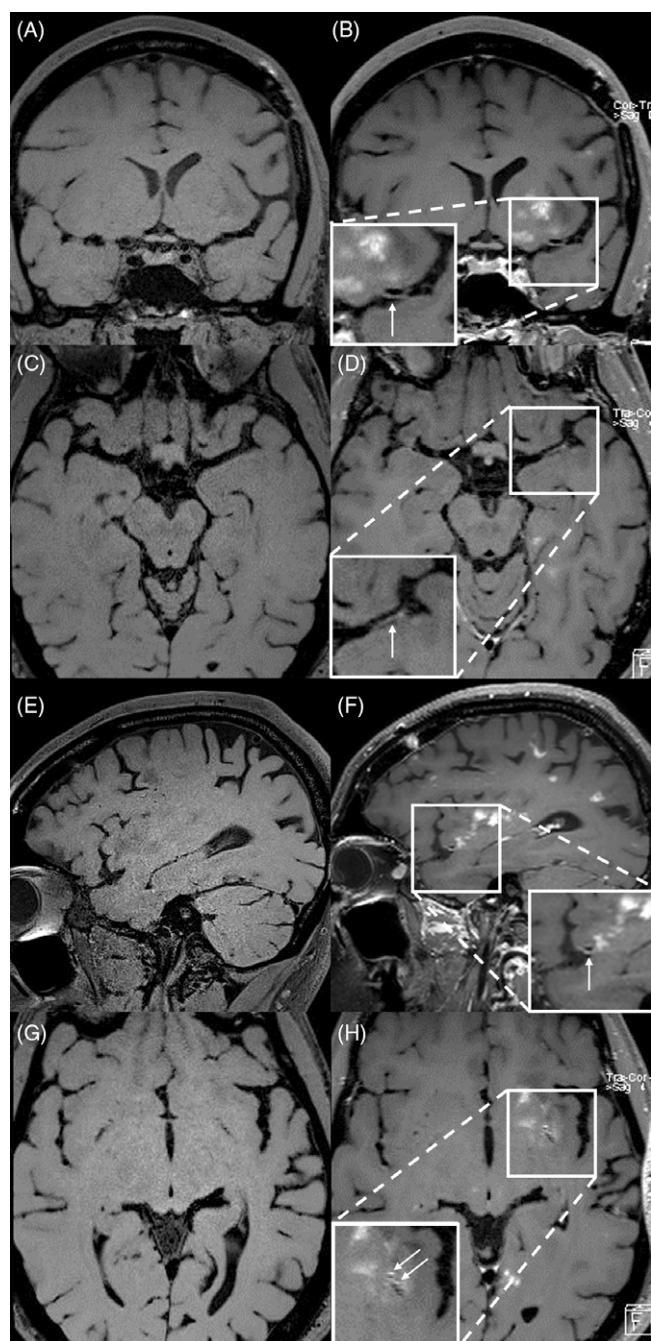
Vessel wall enhancement in unilateral relapsing primary angiitis of the CNS. Compared to pre-gadolinium imaging (A, C, E, G), VW-MRI shows left-sided middle cerebral artery M1 segment (B, D, F, arrows) and lenticulostriate (H, arrows) vessel wall enhancement post-gadolinium.
